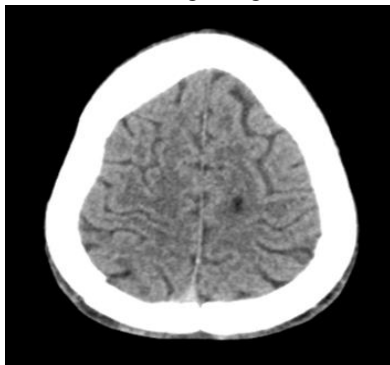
Initial non-contrast brain CT scan. Axial CT image in soft tissue window shows left precentral gyrus contusion (arrow).
